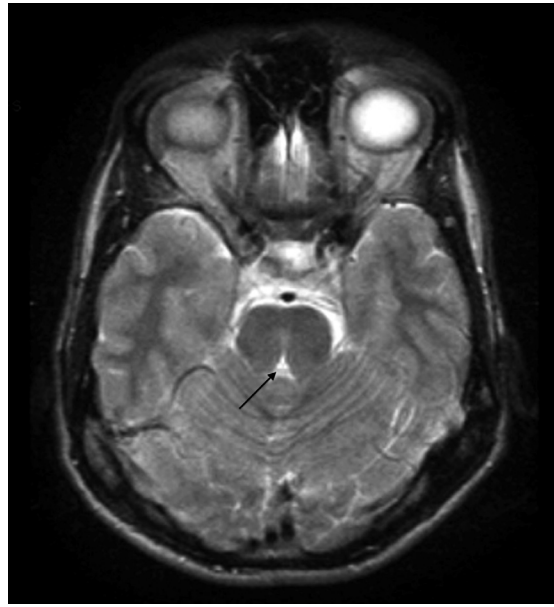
MRI axial view showing the brainstem (pointed by the arrow) with a midline split in the medulla and pons; and a midline groove in a small vermis.
